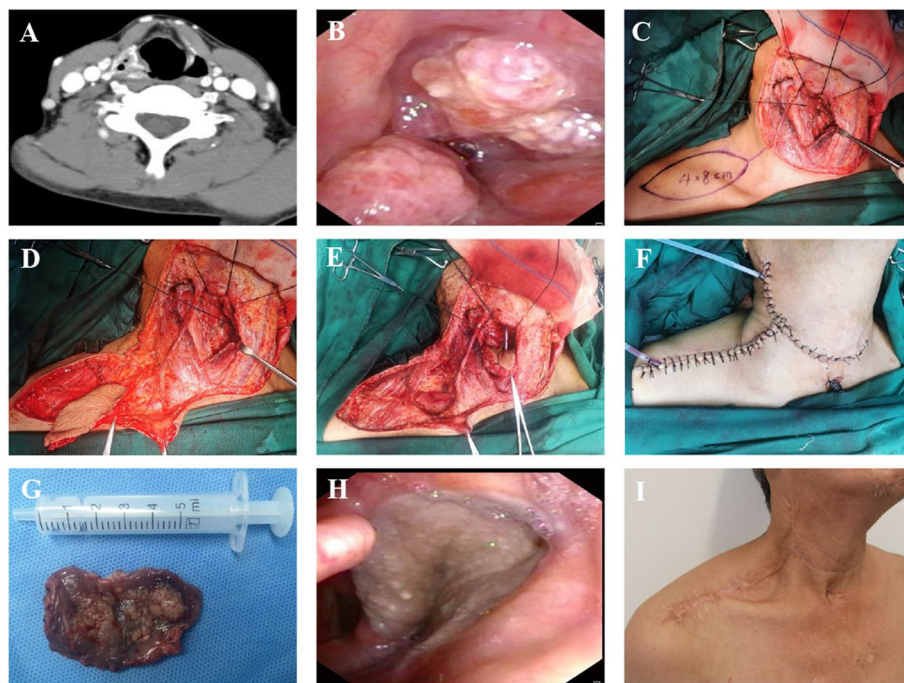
The treatment and surgical process for a patient with right pyriform fossa carcinoma. A CT Manifestations of right pyriform fossa carcinoma. B Right pyriform sinus carcinoma under electronic laryngoscope. C After thorough resection of the tumor, design a supraclavicular flap based on the location and size of the defect. D Harvest supraclavicular flap. E Repair of right pyriform fossa and arytenoepiglottic wall with supraclavicular flap. F Immediate postoperative situation. G The resected tumor of right pyriform fossa. H One and a half years after surgery, the appearance of right pyriform fossa. I One and a half years after surgery, the appearance of neck and shoulder
